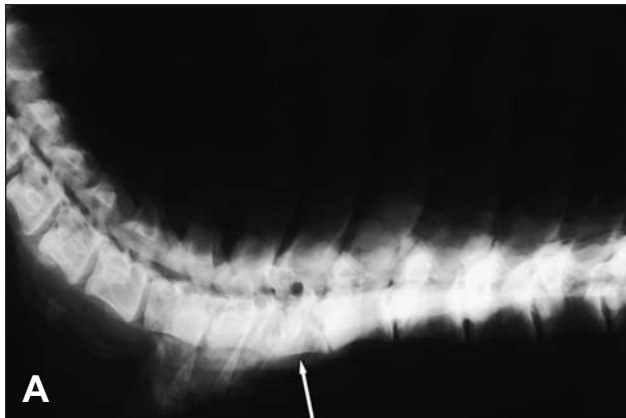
Same radiographic views as in Figure 1. Notice that the third thoracic vertebra is abnormally shaped (arrow) and the adjacent intervertebral disk space is narrow, compatible with a hemivertebra.
